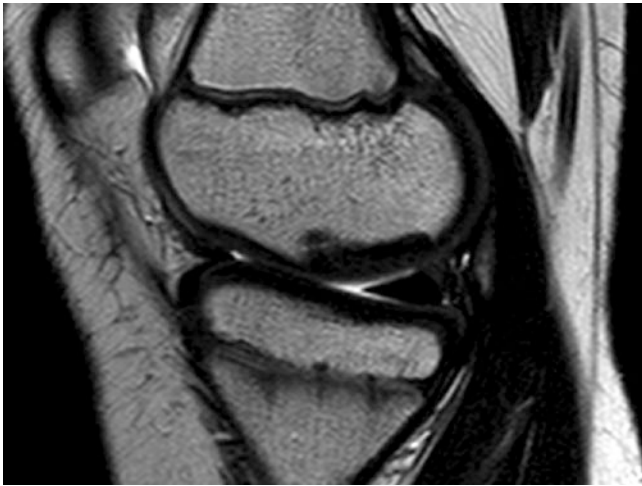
Osteochondral fragment on MRI. There is a well-defined focal signal abnormality at the cortical surface of the medial femoral condyle, the commonest site
